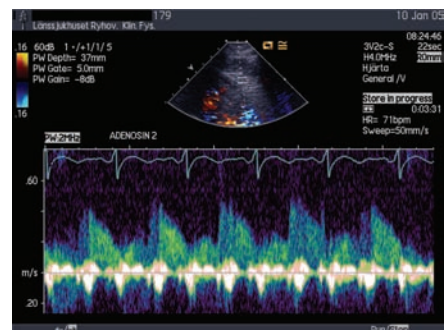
Spectral Doppler recording of the LAD flow during stress
